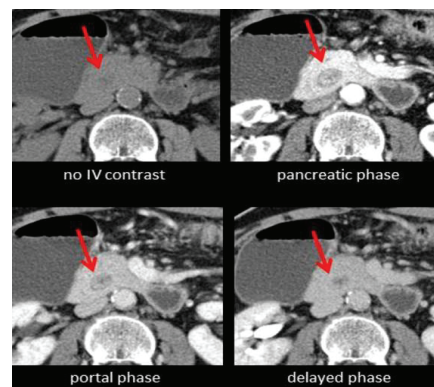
CT images: Annular pancreas
